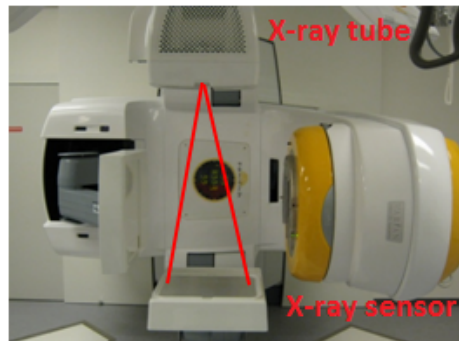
Integrated cone beam CT and medical linear accelerator at Rigshospitalet.
